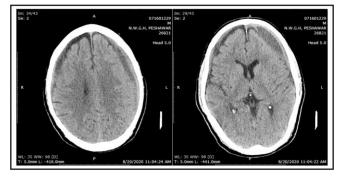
CT of Bilateral Hematoma (scan included with patient's permission).
